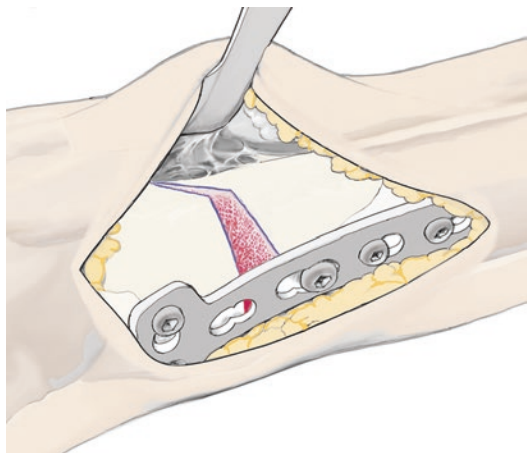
Fixation is started with the distal locking screws, then a lag screw is used for the screw closest to the osteotomy site. This pulls the tibia against the plate. The two proximal locking screws are then inserted. Radiographs in two planes
